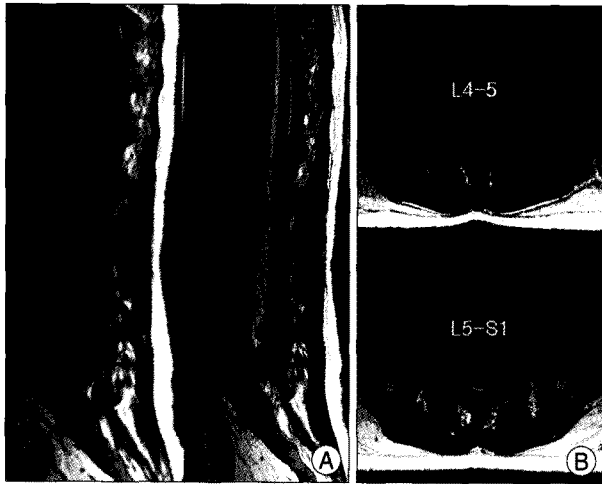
A : Preoperative sagittal T1- and T2-weighted images show the downward extruded disc at L5-S1 combined with cystic lesion (arrow), which is isointense on T1- and hypointense on T2-weighted images. B : Pre-operative axial T2-weighted images show a cystic lesion at the spinal intradural extramedullary location.
